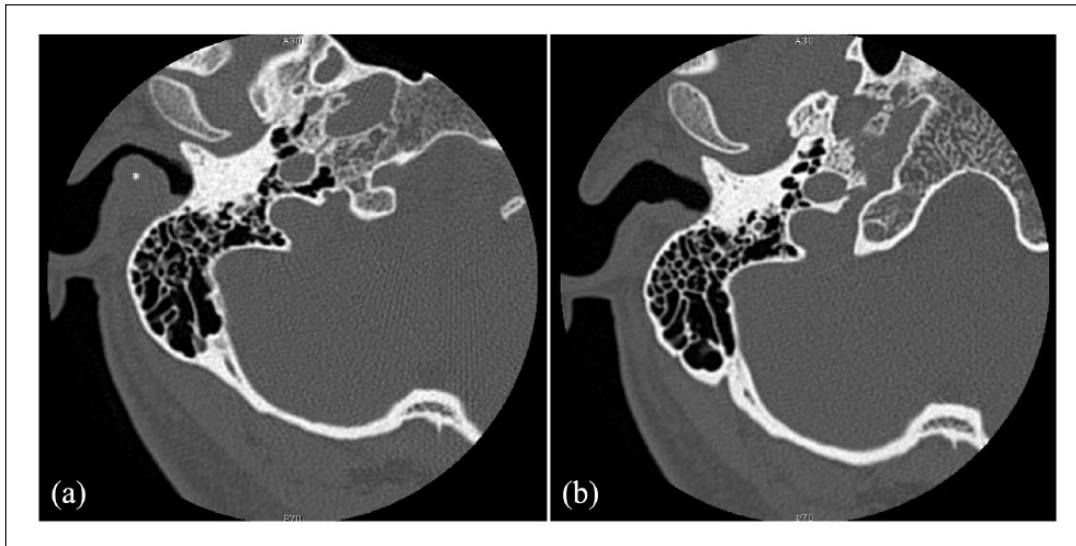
(a) CT imaging (horizontal plane) of CA (asterisk) in the right external auditory canal with no bone invasion. (b) A control CT scan was performed 1 year after surgery showing no recurrence.
